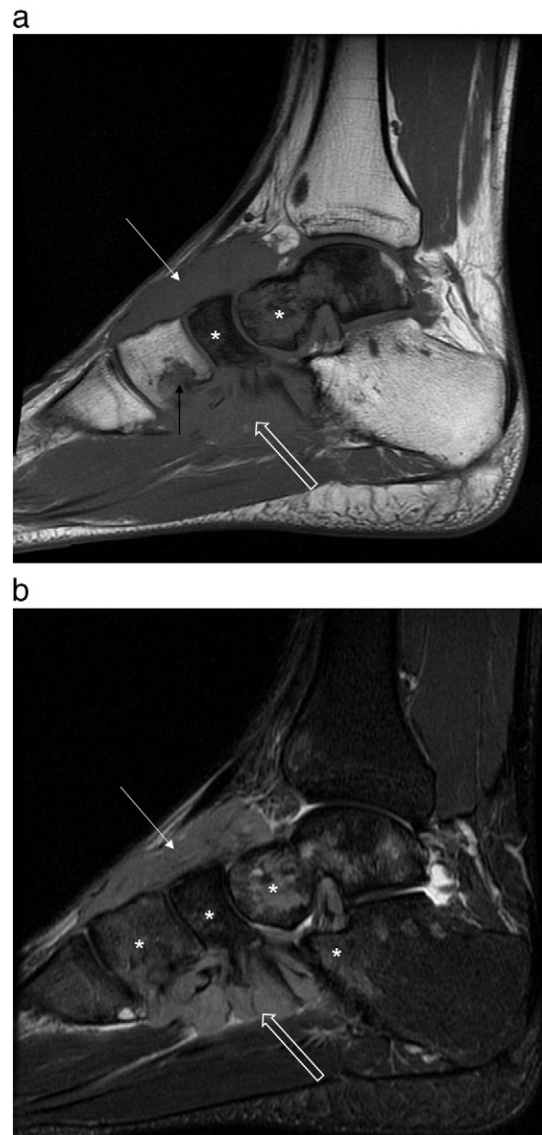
(a) Sagittal T1-weighted image of a 17-year-old man with a malignant GrCT of the left foot. The soft tissue mass over the dorsal aspect (white arrow), which infiltrates the deep plantar compartment (open white arrow), demonstrates diffuse intermediate T1-weighted signal intensity. Mixed low-to-intermediate T1-weighted hypointensity replacing the normal fatty marrow signal of the talus and navicular bones (white asterisks) is suspicious for tumor involvement. Tumor infiltration of the medial cuneiform is also noted (black arrow). (b) Sagittal T2-weighted fat-suppressed image of a 17-year-old man with a malignant GrCT of the left foot. There is intermediate T2-weighted signal intensity of the infiltrative mass over the dorsal aspect of the midfoot (white arrow), which infiltrates the deep plantar compartment of the midfoot and anterior hindfoot (open white arrow). Patchy intermediate T2-weighted marrow signal intensity suspicious for tumor involvement is most pronounced within the talus and is also seen in the anterior process of the calcaneus, navicular, and medial cuneiform bones (white asterisks).
